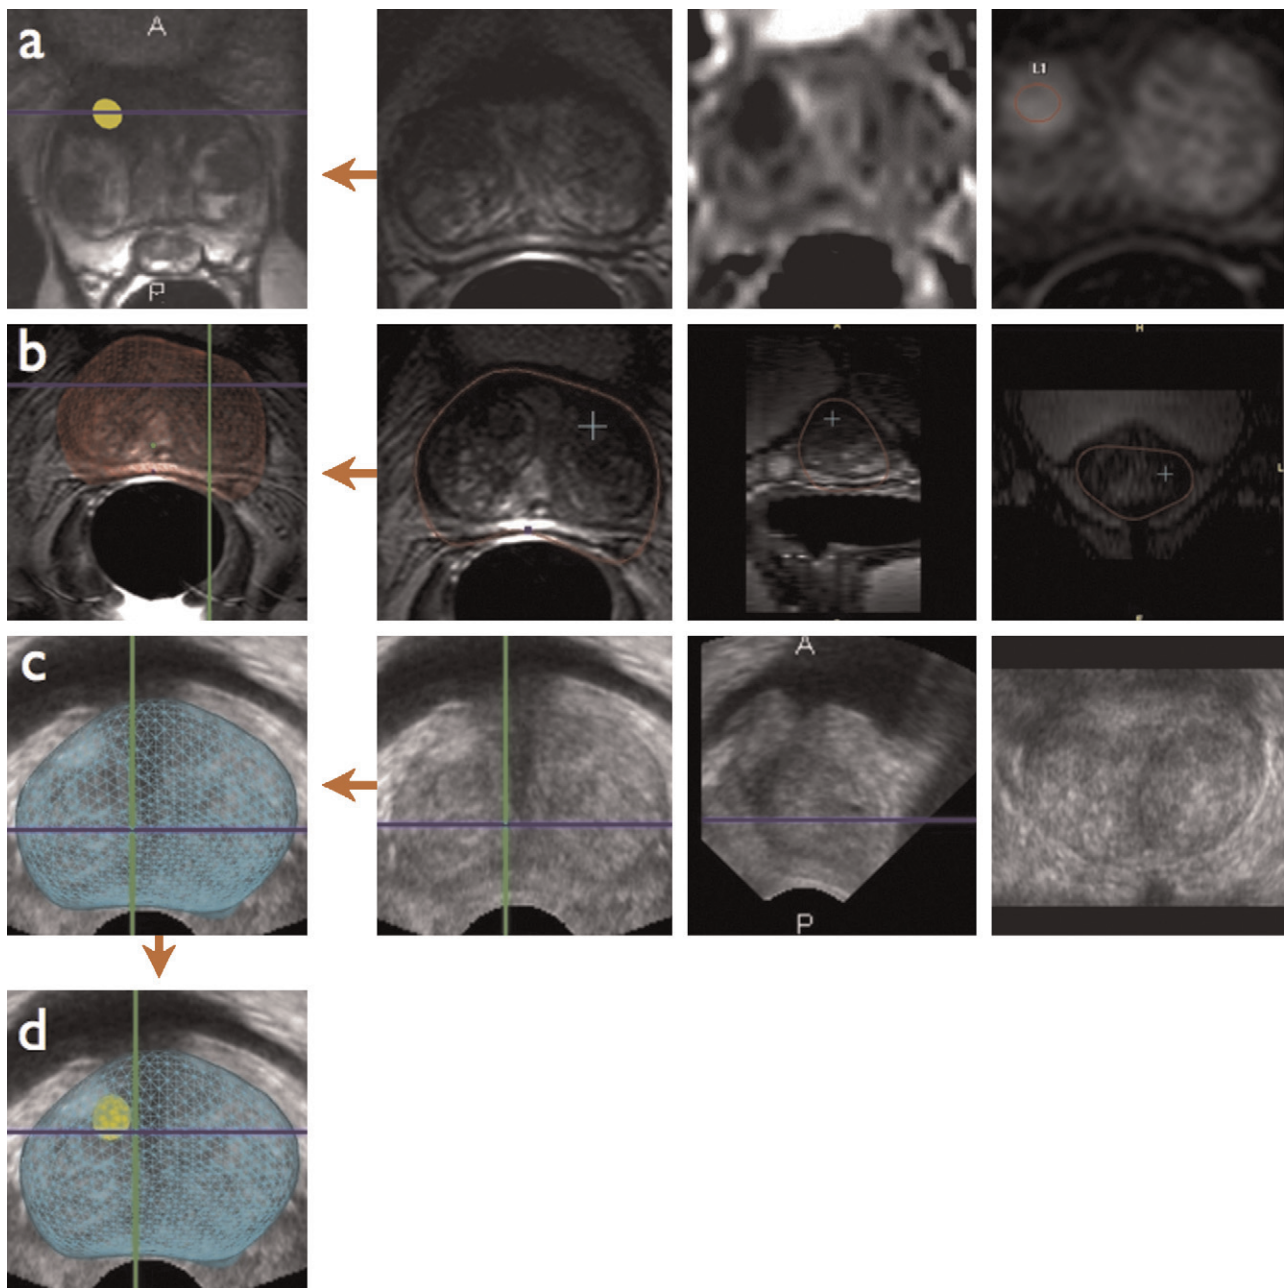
Target definition and elastic surface registration, axial representations of the prostate, are presented in the first column. (a) T2-weighted magnetic resonance imaging (MRI), diffusion-weighted imaging MRI, and dynamic contrast-enhanced MRI demonstrate a European Society of Urogenital Radiology score sum (ESUR-S) of 13 lesion in the anterior aspect of the right transition zone that is highlighted by a yellow tag in the first column. (b) Surface reconstruction from MRI; the prostate volume is contoured in the axial, sagittal, and coronal T2-weighted MRI acquisitions. (c) Surface reconstruction of three-dimensional transrectal ultrasonography (3D TRUS). (d) Elastic surface registration by means of an algorithm that controls the prostate constraints driven by changes in the patient's positioning, deformations in rectal wall, or displacement of the prostate. After registration, the MRI-suspicious areas highlighted by colored tags could alternatively be displayed within MRI- or 3D TRUS-registered volumes.
